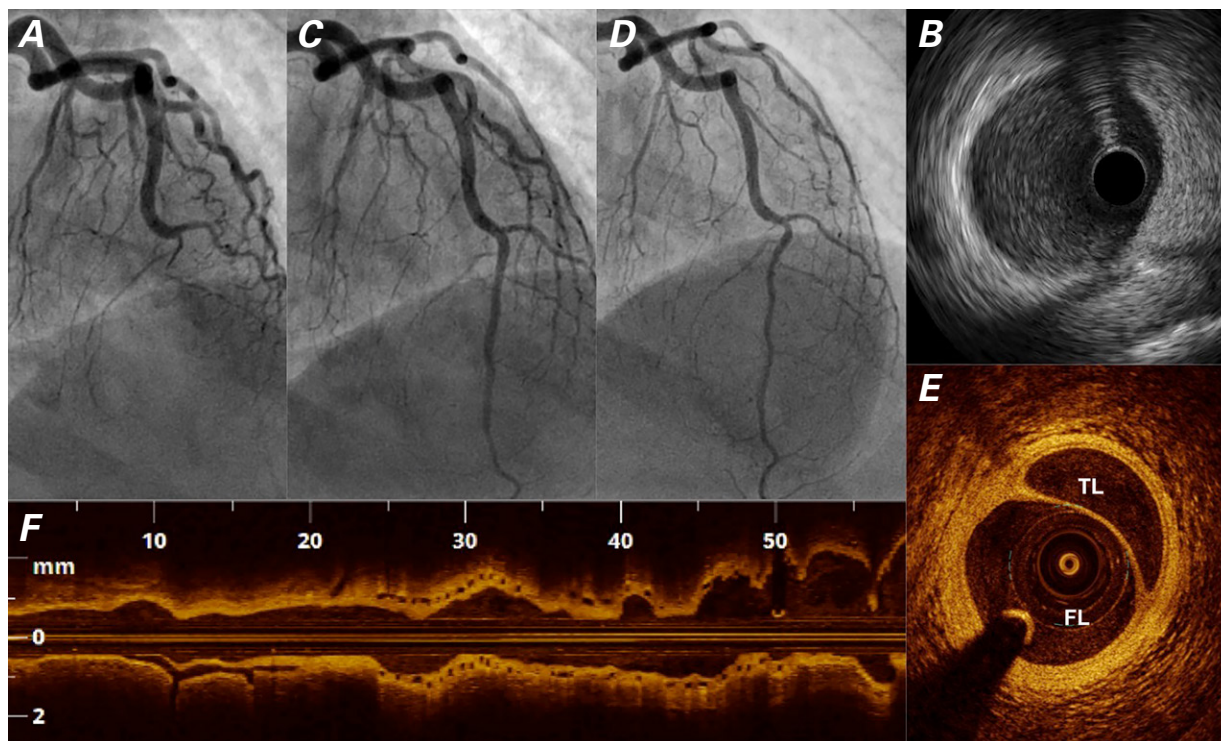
Patient 3. A) Angiogram shows the left anterior descending coronary artery (LAD) with occlusion from the 2nd diagonal branch to the end of the vessel and Thrombolysis in Myocardial Infarction grade 0 flow. B) Diagnostic intravascular ultrasonogram shows a type 1 spontaneous coronary artery dissection after the guidewire is crossed. Angiograms show results C) after intervention and D) at one year. Optical coherence tomograms in E) axial and F) long views, obtained at one year, show excellent results with a small dissection on the distal LAD.
